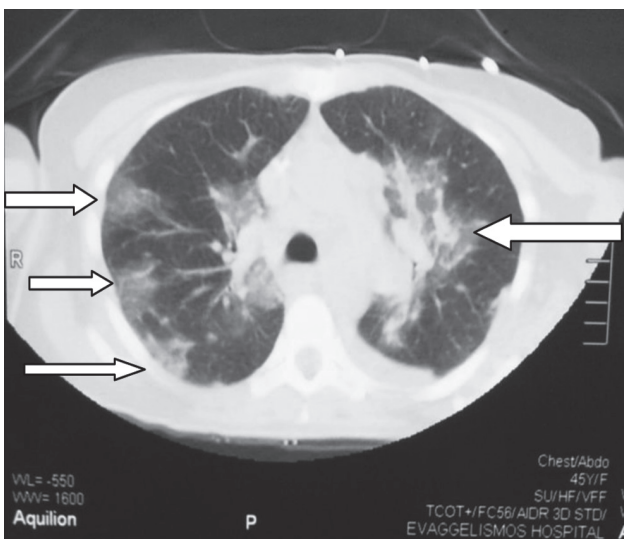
CT of the chest showing multiple ground glass infiltrates (arrows).
